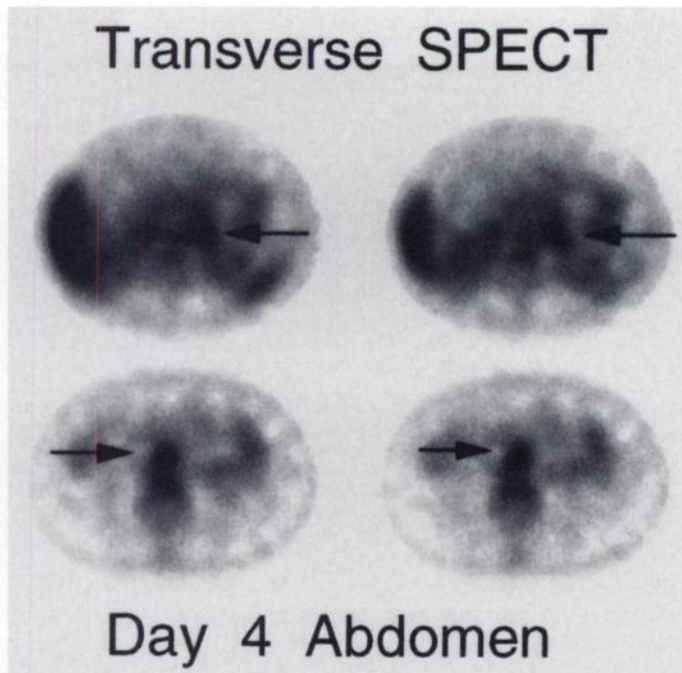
Day 4 transverse SPECT images of the abdomen. Uptake in lymph nodes near the aortic bifurcation is indicated with arrows in the two lower images. Uptake in periaortic lymph nodes on the left side of the patient is indicated by arrows in the upper two images.
